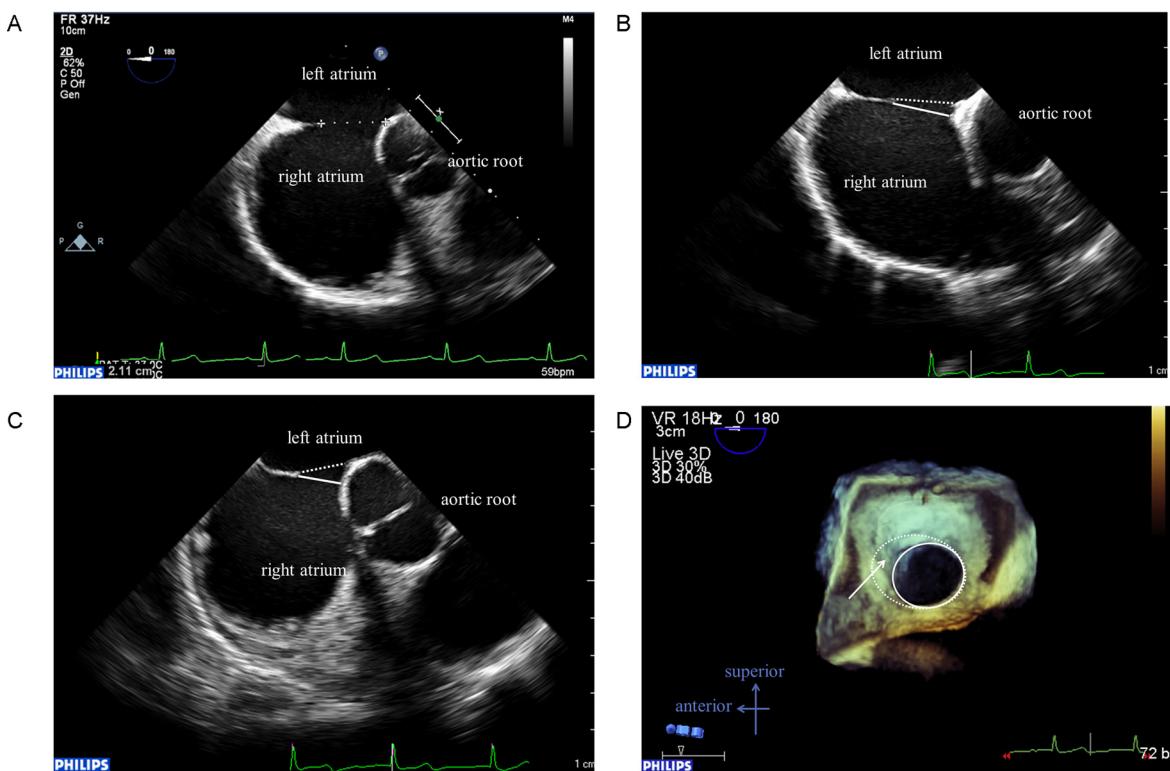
Transesophageal echocardiography (TEE) images of atrial septal defect before the procedure. (A) Two-dimensional 0° TEE image shows that the maximal defect diameter of septum primum was 21 mm. (B and C) Two-dimensional 30° TEE image shows that the defect surface of the septum primum (dotted-line) is different from that of the septum secundum (solid-line). Images of the defect on end systolic phase (B) and early diastolic phase (C). (D) Three-dimensional TEE image shows an en face view from the left atrium. Arrow indicates the deficient aortic rim. Surface of the left atrial side consists of septum primum (dotted-line) while surface of the right atrial side consists of septum secundum (solid-line). These two surfaces construct the morphological characteristic of the malaligned atrial septum.
